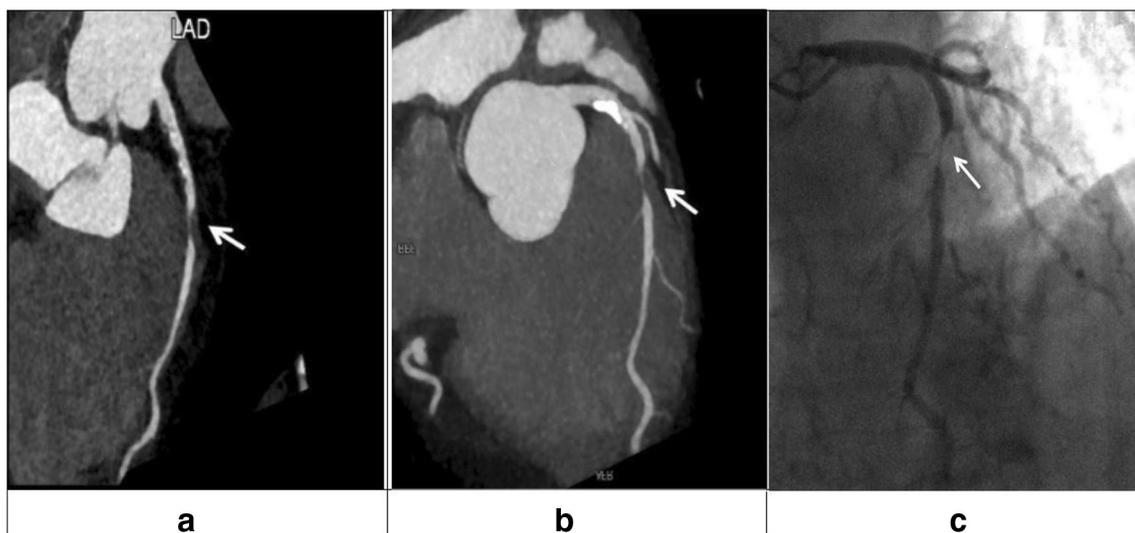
Coronary stenosis by turbo high-pitch coronary computed tomography angiography and invasive coronary angiography for a 57-year-old man with chest pain (mean heart rate = 62, body mass index = 23.18, effective radiation dose = 0.35). The curved planar reconstruction image
